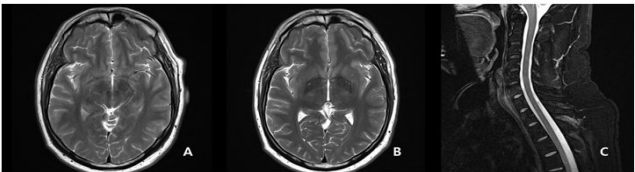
A): No abnormal findings on the MRI performed on the day of visit; B): Additional MRI performed on the 5th day of the visit showed no abnormalities; C): No abnormal findings were found on cervical spine MRI on the 2nd day of visit.
